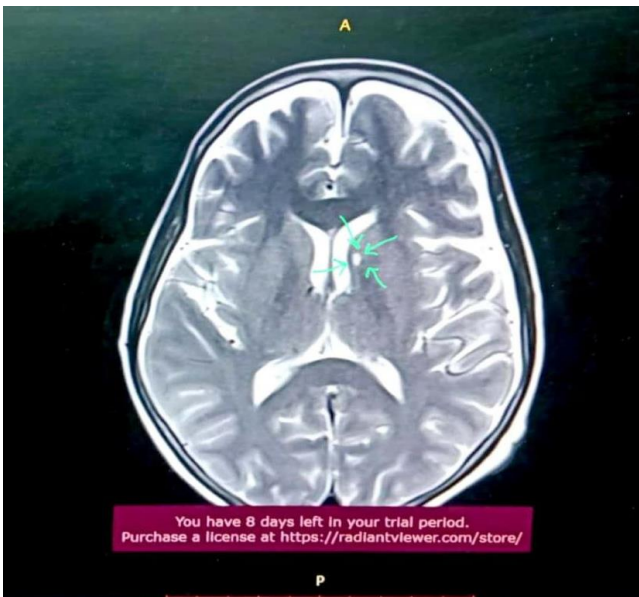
MRI brain of patient X (lacunar infarct is shown by arrows).
